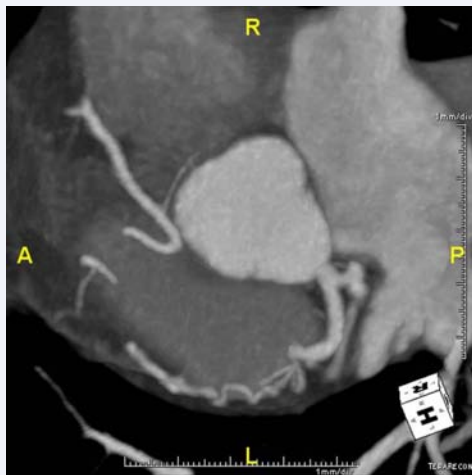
Cardiac CT angiography maximum intensity projection (MIP) rendering of the aortic root and coronary arteries in a short axis projection. The RCA is normal in course and caliber except for ostial atresia.
